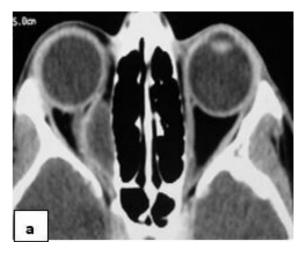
(a): CT scan (axial section) showing a medial orbital subperiosteal abscess on the right side; (b)- CT scan (axial section) showing multiple thick walled cavities (abscesses) in the left medial and lateral extraconal compartment of the orbit.
